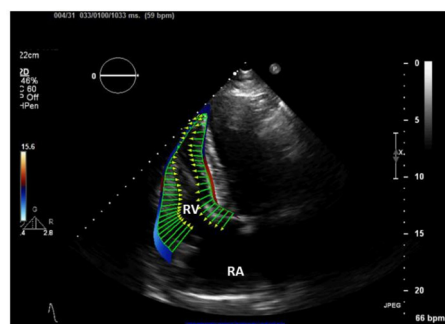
Transthoracic echo with RV speckle tracking based calculation of RV endocardial deformation (green vectors). RA: right atrium; RV: right ventricle
